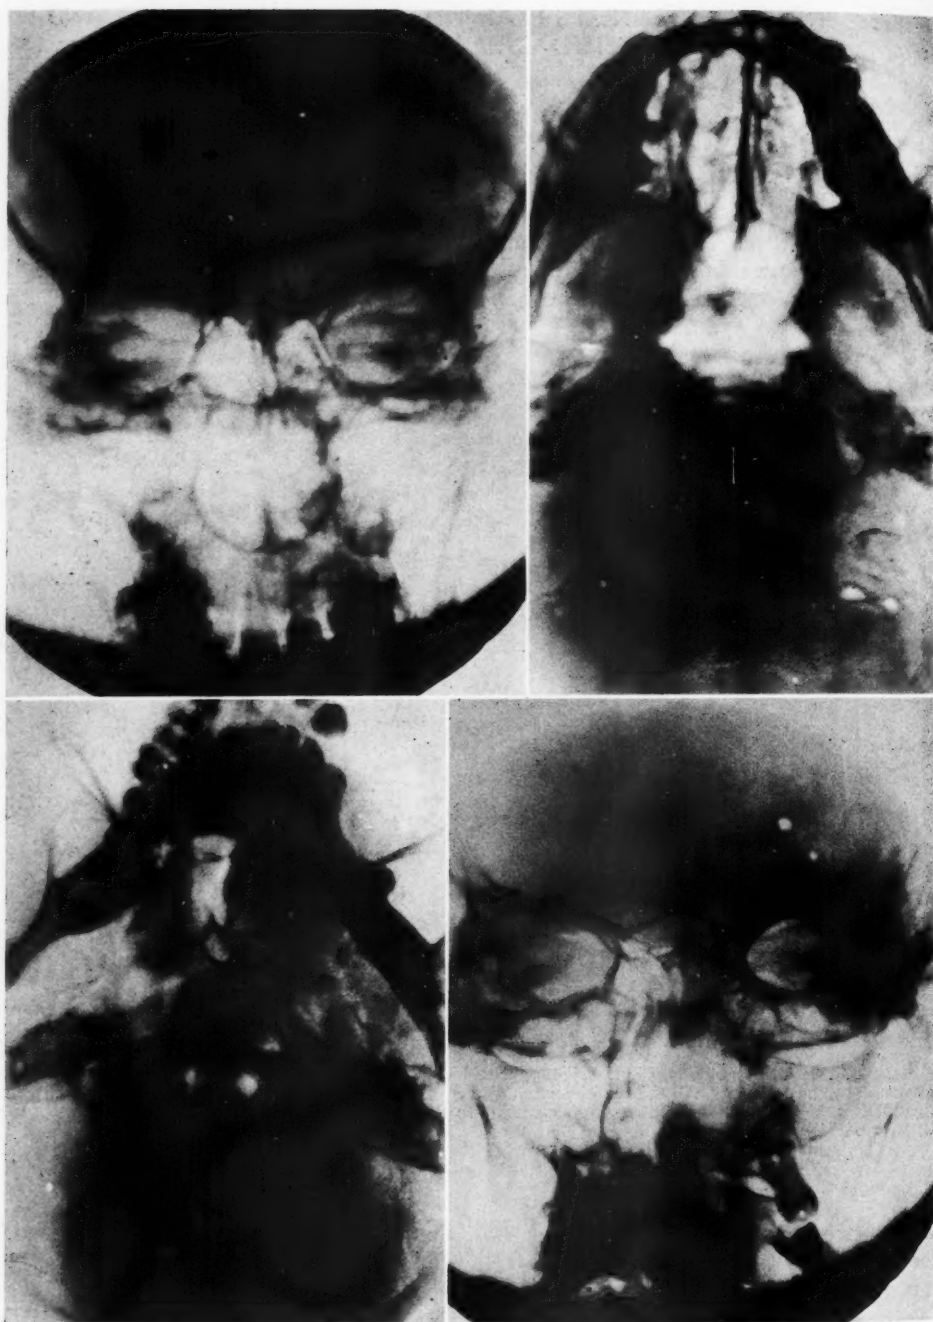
A (*upper left*). Hyperplastic sphenoiditis on the right side. Diagnosed by the rarefaction, broadening, and indistinct lower edge of the right half of the Granger line. Radiograph made in the Granger position.
